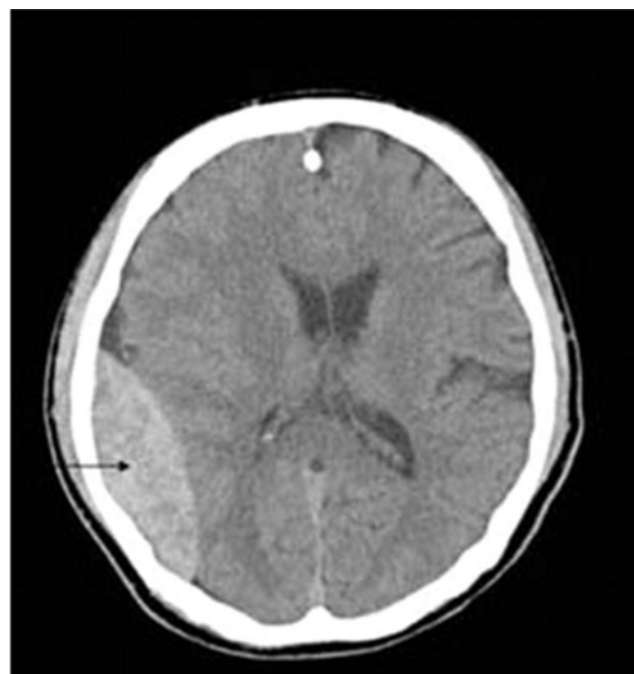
(a): CT scan showing extradural haemorrhage (crescent shaped hyper dense) over right temporal region.
